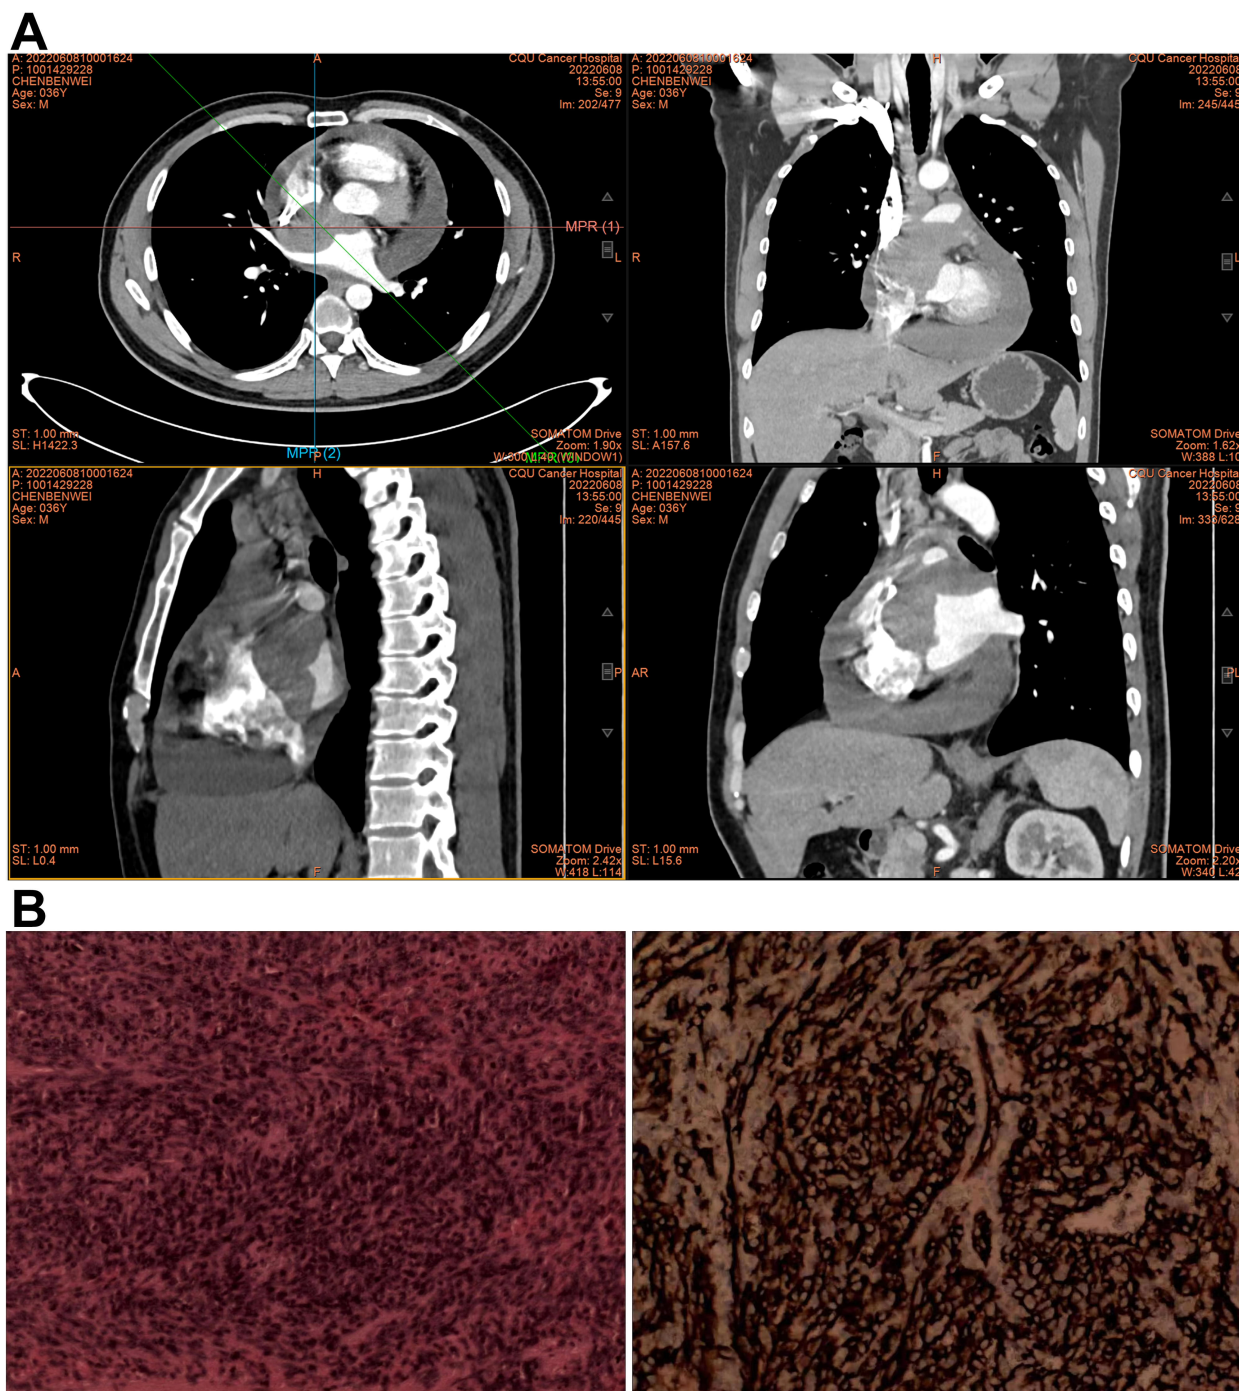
Imaging and pathological examination of a typical case of PCAS. (A) MR image of a right atrial mass involving the pericardium. (B) The tumor infiltrated the myocardial tissue, and the tumor tissue formed an irregular vascular cavity-like structure that was interconnected. The cavity was lined with highly proliferative tumor endothelial cells. Tumor cells with immature vascular cavities and fibrosarcoma-like solid areas were found locally.
